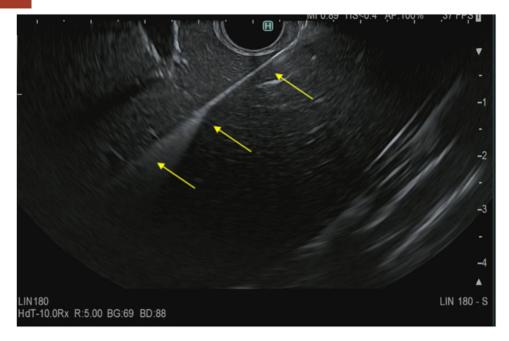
Endoscopic ultrasound image of fine needle biopsy of liver.
